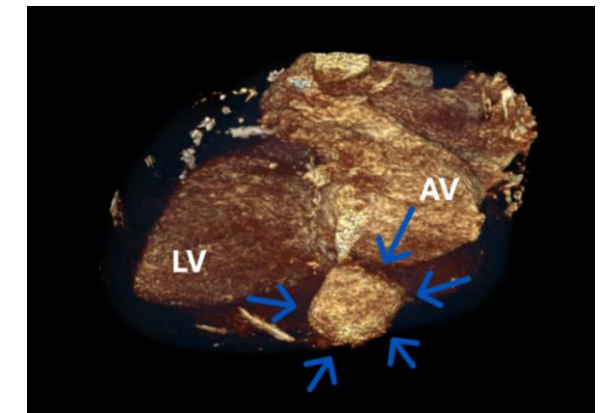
CT images of the lesion.
